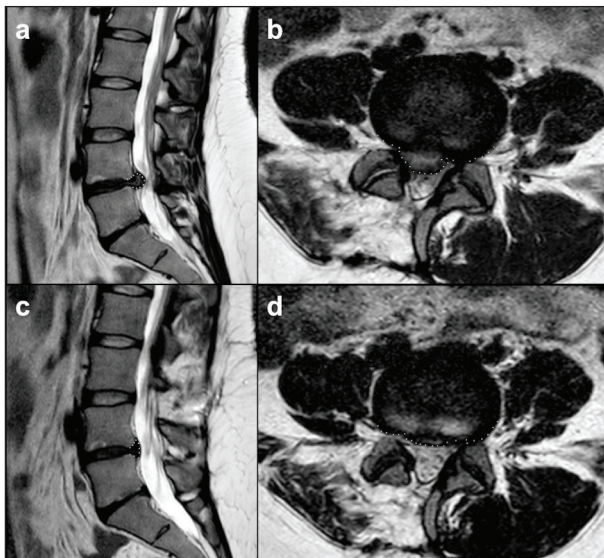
Sagittal and axial TSE-T2w MRI images on the most representative level, showing an example of LDH measurements before (a-b) and after (c-d) intradiscal O₂-O₃ chemiodiscolysis.
